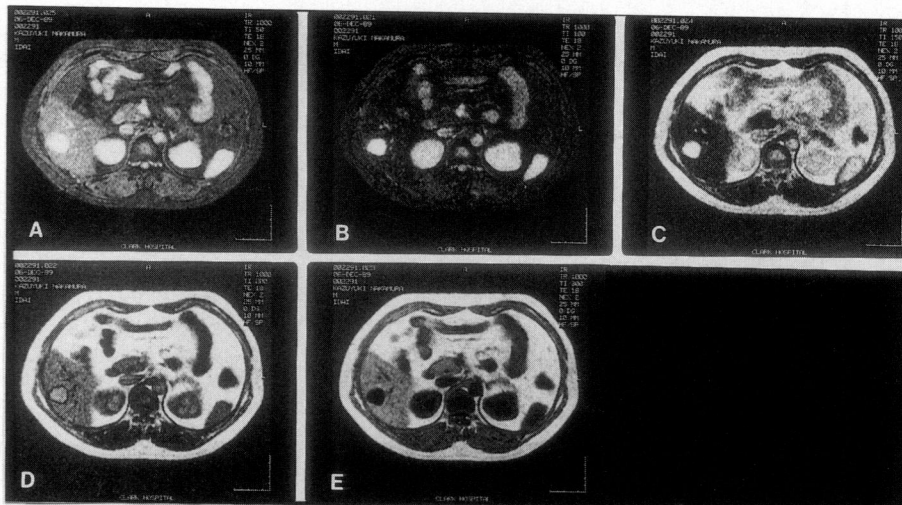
MR imaging of hepatic hemangioma (Fig. 6) by STIR method.
